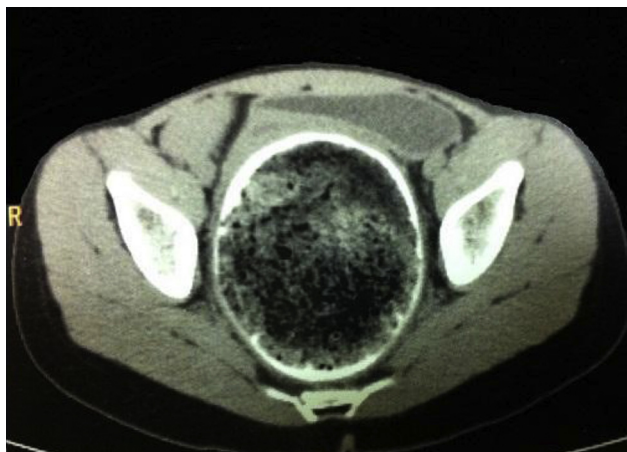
Computed tomography (axial plane) showing rectal fecal impaction with megarectum.
